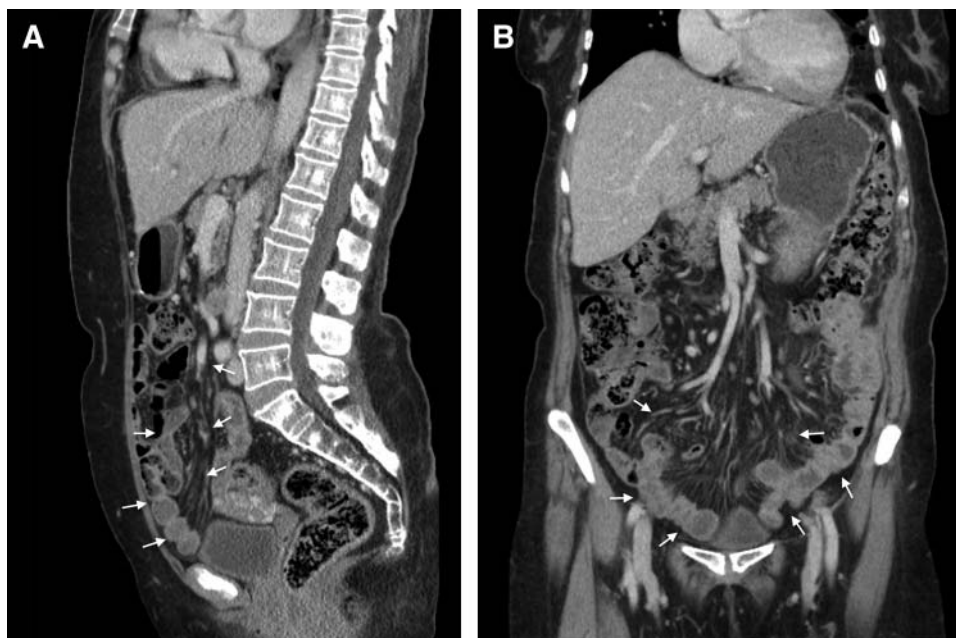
Sagittal (A) and coronal (B) views of an abdominal and pelvis computed tomography scan show thickening of the abdominal organs, specifically of the greater omentum (arrows). Surgical resection of the greater omentum revealed chronic granulomatous inflammation, confirming the diagnosis of gastrointestinal sarcoidosis.
